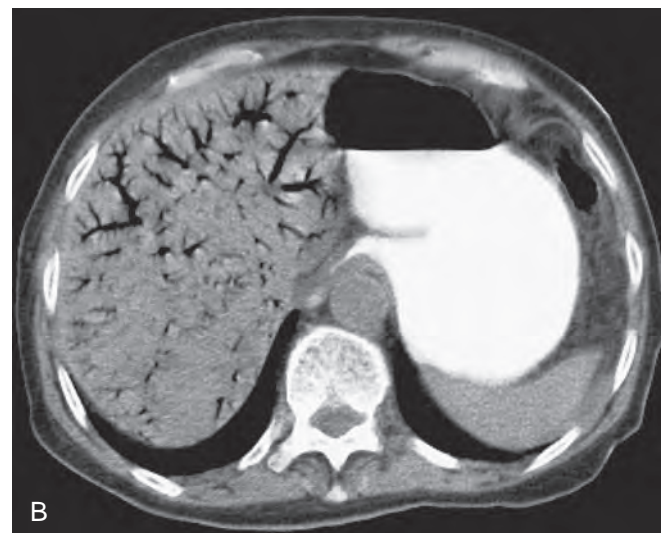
Black enhancement pattern. A. Scan of the pelvis displayed with lung windows shows intramural gas with ischemic necrosis of a segment of ileum. B. CT scan of the liver of this patient shows extensive portal venous gas.
